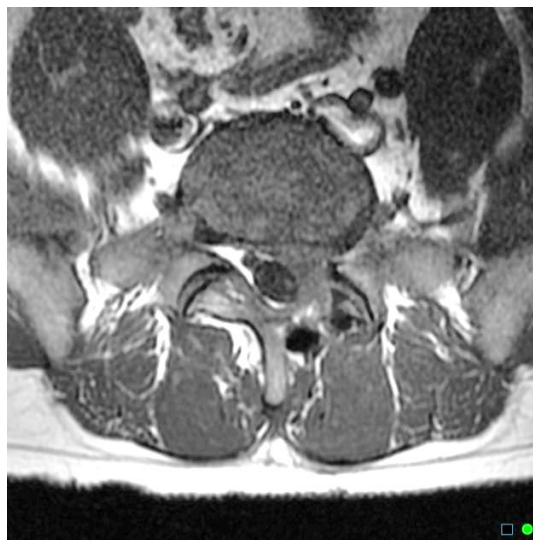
Axial MRI image with L5-S1 left laminectomy obtained at 4 months after the start of the recovery programme
